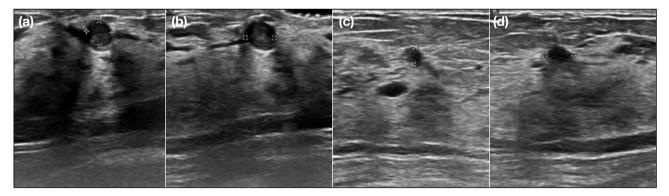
Case 3. A 45-year-old woman with two right breast 12 o'clock position fine needle aspiration-proven intraductal papillomata, one at the subareolar region and the other at 3 cm from the nipple. (a) Transverse and (b) longitudinal ultrasound of right breast 12 o'clock position subareolar lesion. (c) Transverse and (d) longitudinal ultrasound of right breast 12 o'clock position 3 cm from nipple lesion, measuring $3 \times 3 \times 5$ mm.
